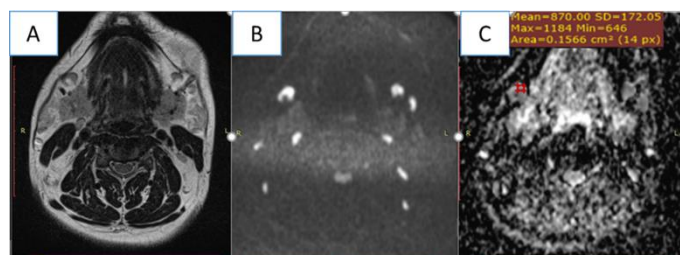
MRI images of case 4. A 24-year-old Male exhibited a painful, palpable upper cervical lymph node on the right side. Axial MRI images A)
